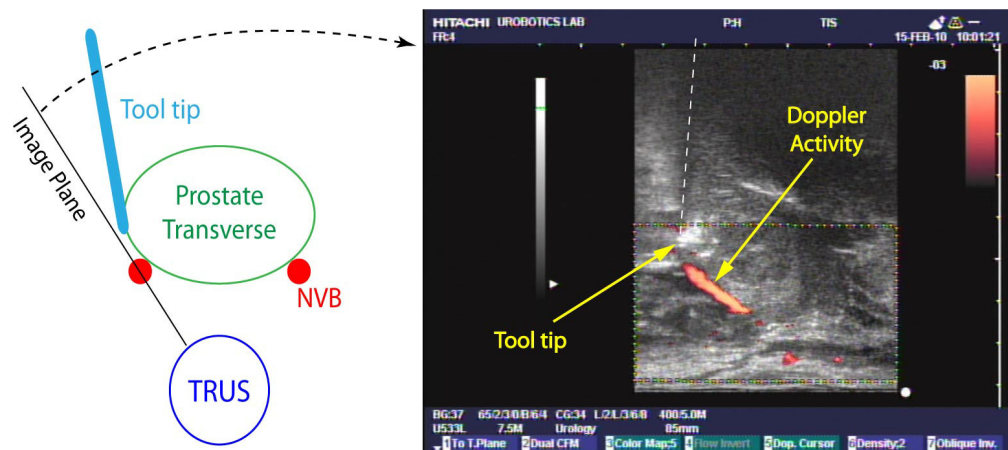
Doppler ultrasound image of the prostate
